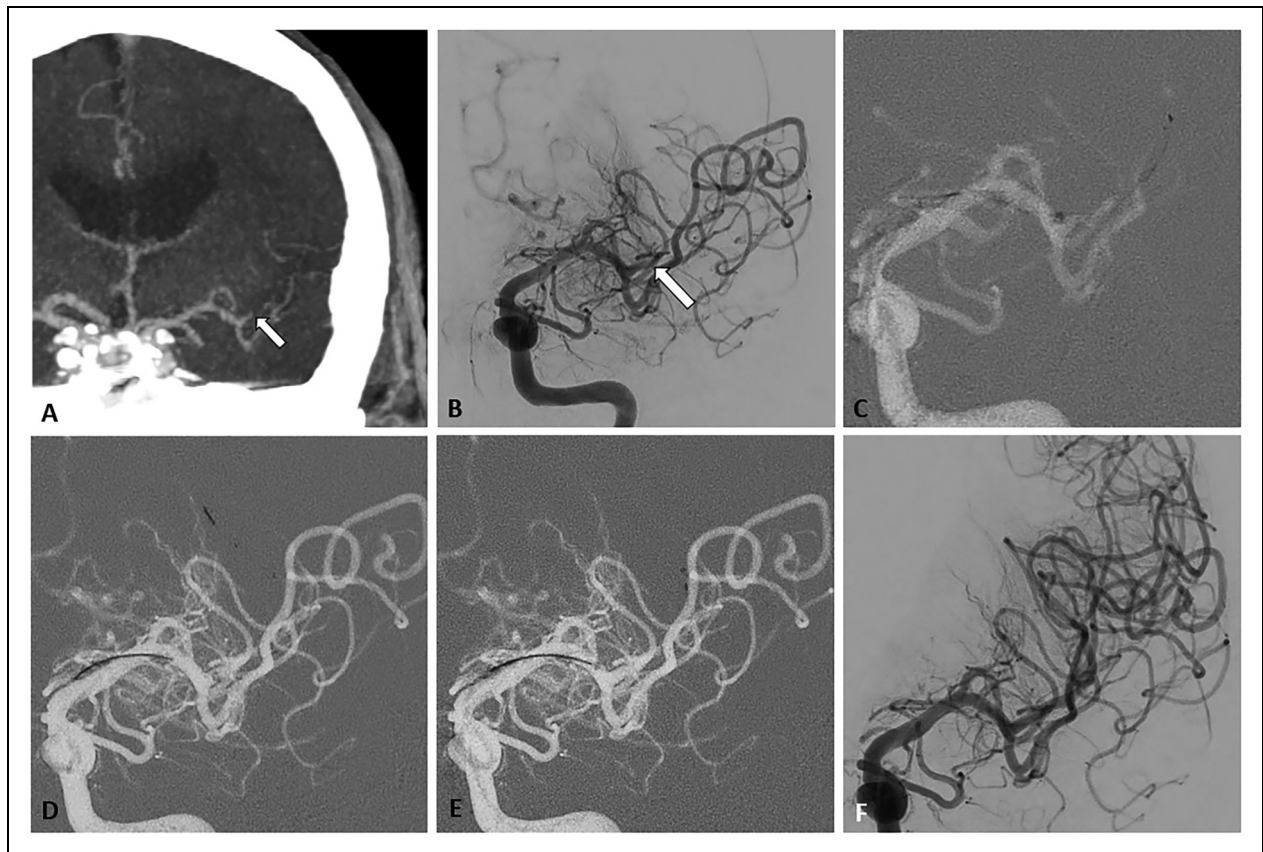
72-year old male patient with wake up stroke (initial NIHSS 15; mRS 2; ASPECTS 8) due to an M2 occlusion of the left middle cerebral artery (MCA). The coronal CT angiography (A) and digital subtraction angiography in p.a.-view (B) depict an occlusion (mTICI 0) of the M2 branch (superior trunk) of the MCA (white arrow). Two unsuccessful mechanical thrombectomy attempts were performed with a conventional stent retriever (CSR) of 4 mm × 22 mm size (C) followed by another 2 futile maneuvers with another CSR of 5 mm × 37 mm size (D). After two recanalisation attempts with the NSR (E), successful recanalisation (mTICI 2b) was achieved within a groin-to-recanalisation time of 80 min (F). Patient recovered with an NIHSS of 3 and mRS of 3 at discharge with an unchanged ASPECT score of 8.
